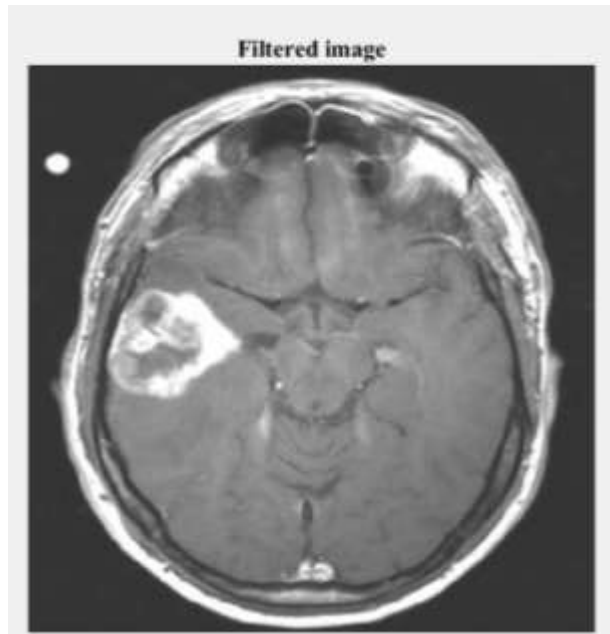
Filtered Input MRI image
